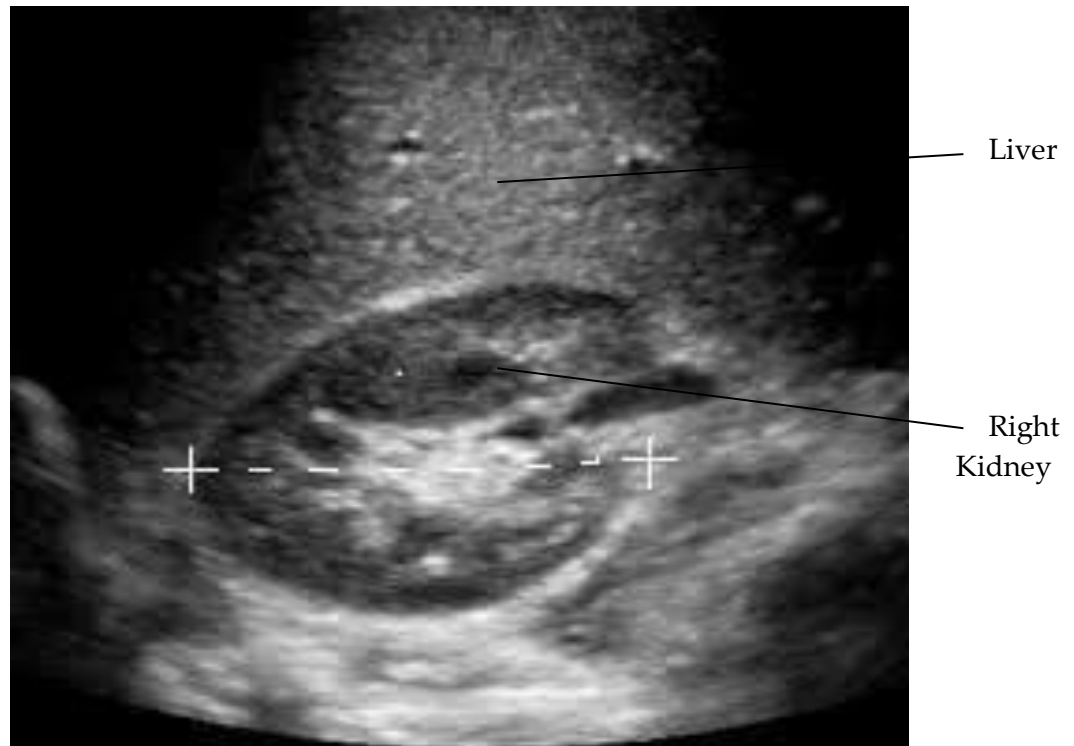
Transverse ultrasound image of the right kidney showing measurement of the transverse diameter
